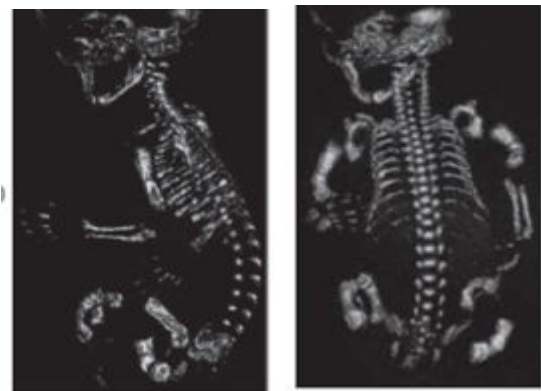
3D CT of OI type II fetus with curved limbs. (a) side view; (b) front side [33].
